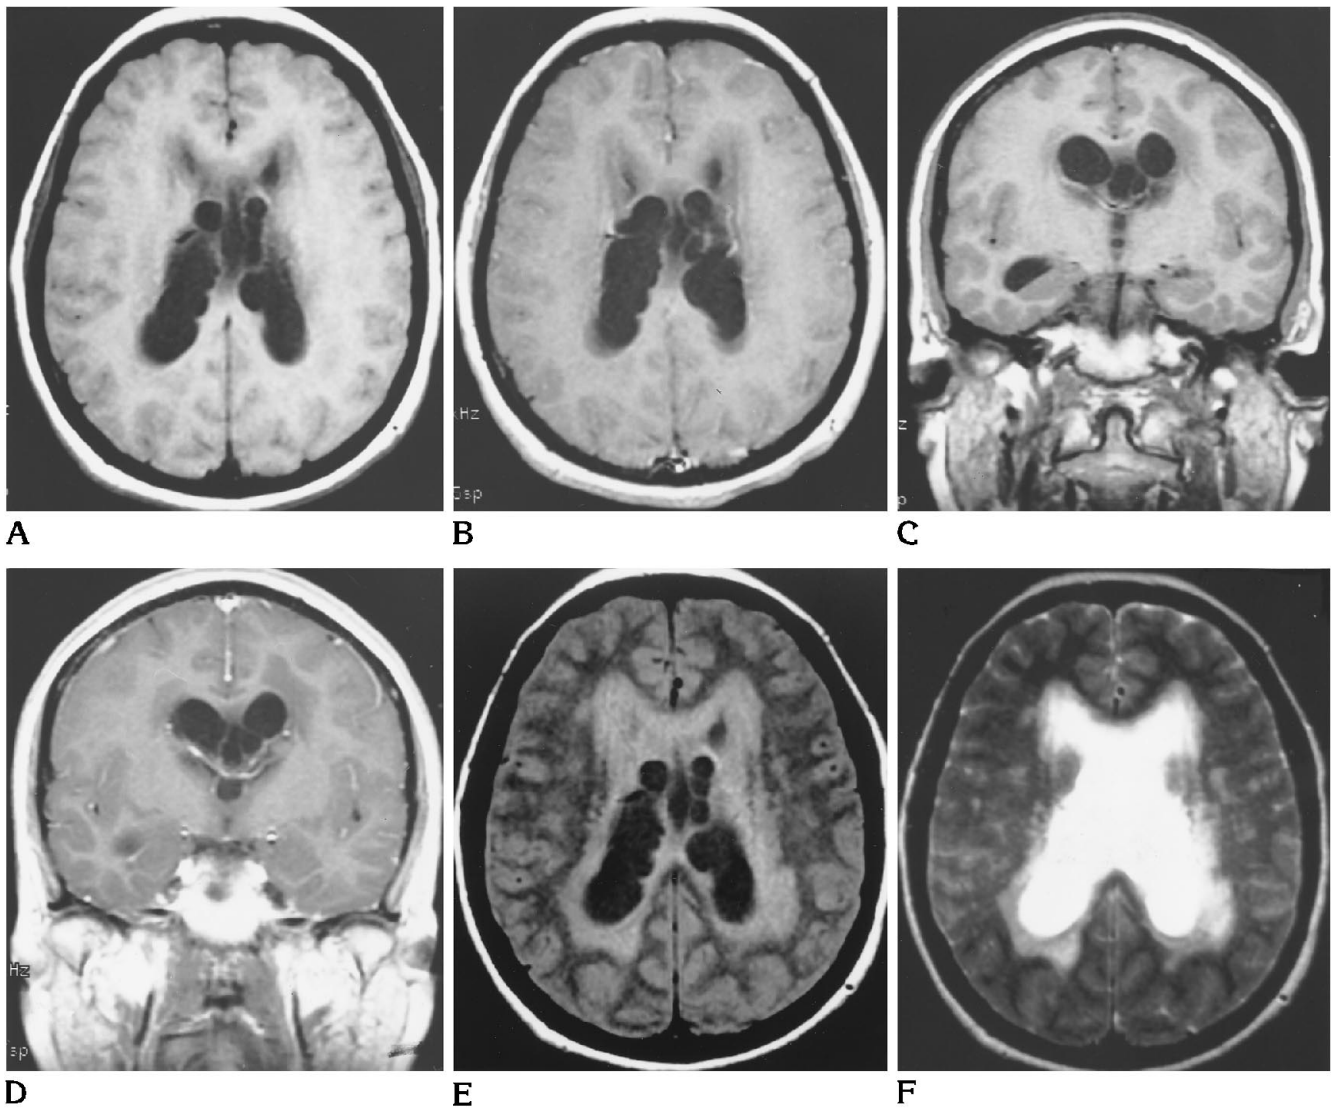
Before surgery, pregadolinium (A) and postgadolinium (B) axial, pregadolinium (C) and postgadolinium (D) coronal T1-weighted, axial proton-density (fast spin-variable echo, echo train 4/8) (E), and T2-weighted (F) MR images demonstrate multiple, nonenhancing intraventricular cysts that follow the signal characteristics of CSF with T1 and T2 weighting. On proton density-weighted images, the cyst contents remain lower in signal intensity than CSF. Cysts involve the lateral and third ventricles. There is no significant solid component associated with the cysts. Moderate dilatation of the lateral and minimal dilatation of the third ventricles, as well as associated periventricular signal changes consistent with transependymal flow of CSF, are noted. Incidentally, regions of high signal on T2-weighted images consistent with underlying small-vessel disease are noted. The subarachnoid space appears normal.
